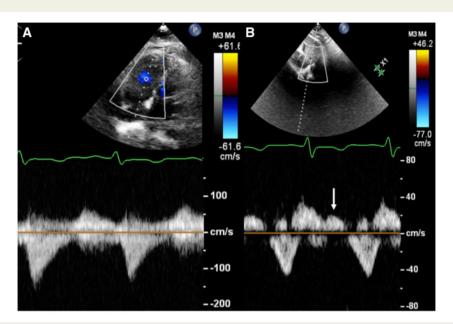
Spectral Doppler of the tricuspid regurgitation. (A) Continuous wave Doppler of the TR jet, showing a low velocity triangular shape, typical of severe TR. (B) Pulsed wave Doppler of the hepatic veins showing systolic flow reversal (arrow). TR, tricuspid regurgitation.
